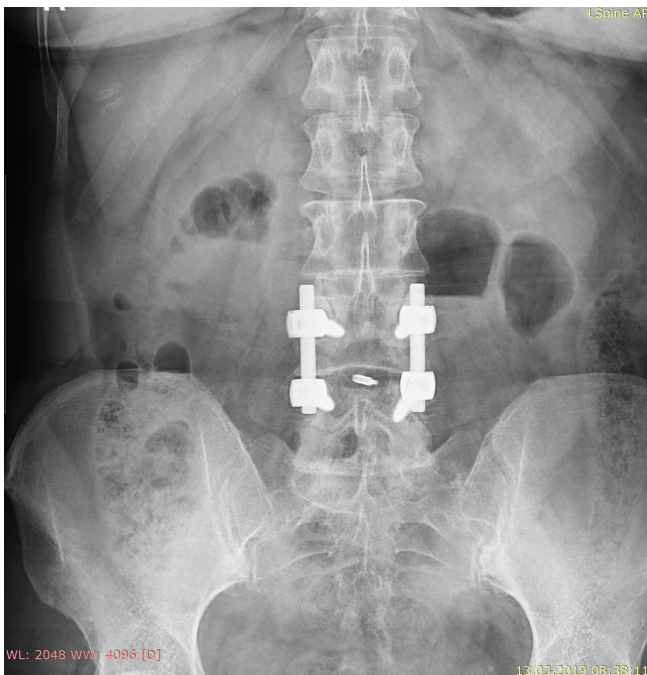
Stage 0 fusion. There is no new bone formation at the lateral side of the lumbar vertebrae on the posteroanterior lumbar roentgenography
